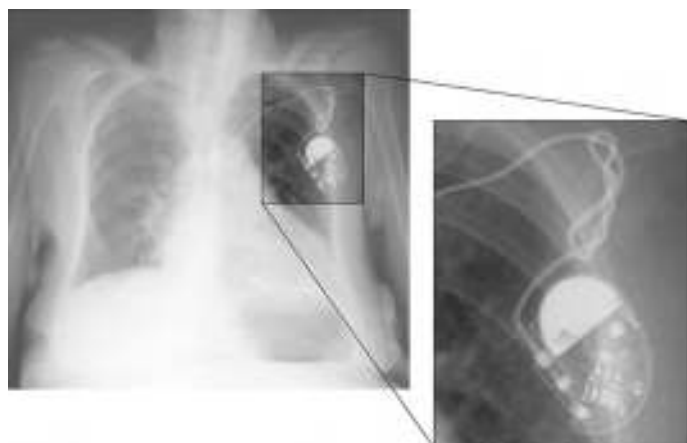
Chest radiograph of a patient with Twiddler syndrome. Note the twisted lead. (Used with permission from reference 7.)
